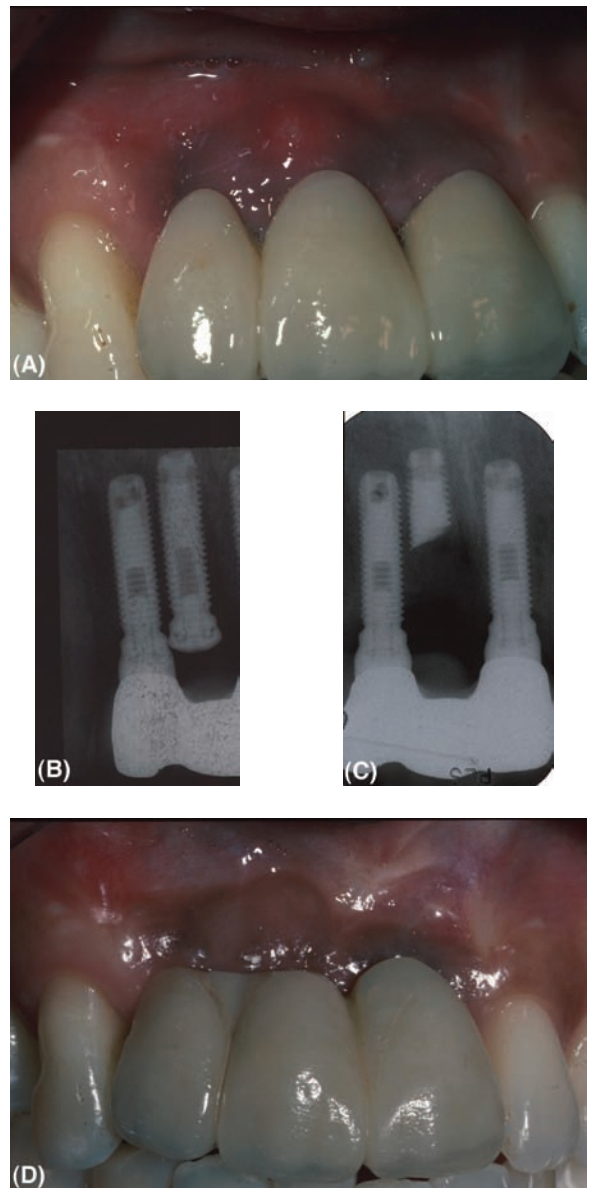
(A) Clinical appearance of a three-unit implant-supported bridge replacing a maxillary right lateral incisor and both central incisors. A small soft tissue abscess is visible at the right central incisor unit. Initially three implants had been inserted to replace each of the missing teeth as single units. (B) A radiograph of the bridge shows that there is a buried unused implant beneath the right central incisor unit in very close proximity to and in intraoral communication with the implant in the right lateral incisor region. This has led to a submucosal infection at the head of the buried implant. (C) The buried implant at the right central incisor site had been deemed to be unrestorable as an individual unit and it proved impossible to remove by trephining to resolve the infection. Therefore, the coronal part of the implant was sectioned and removed, leaving the apical part in situ. (D) The healed result with resolution of the infection. The loss of soft tissue contour necessitated addition to the bridgework. The bridge was then remade. This problem could have been avoided by placement of two implants in the limited space, rather than placing three implants too close together.
